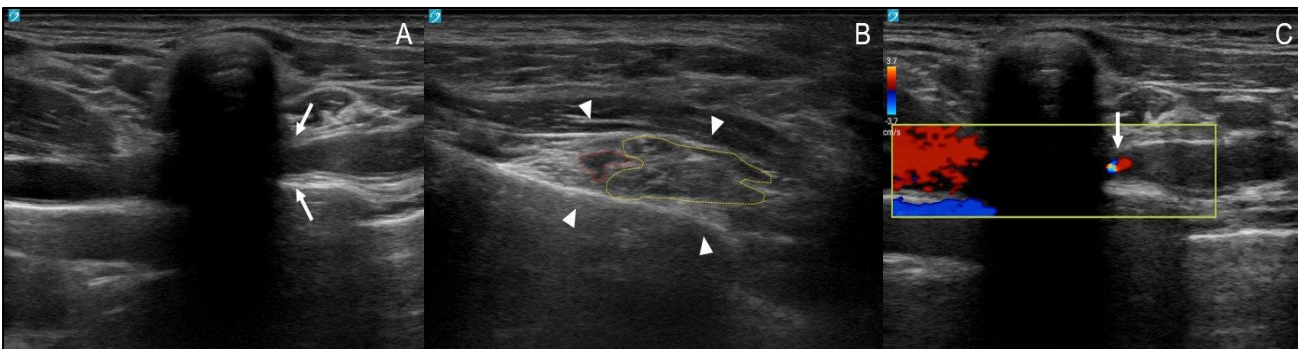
Ultrasonographic findings during the compression-provoking position.
